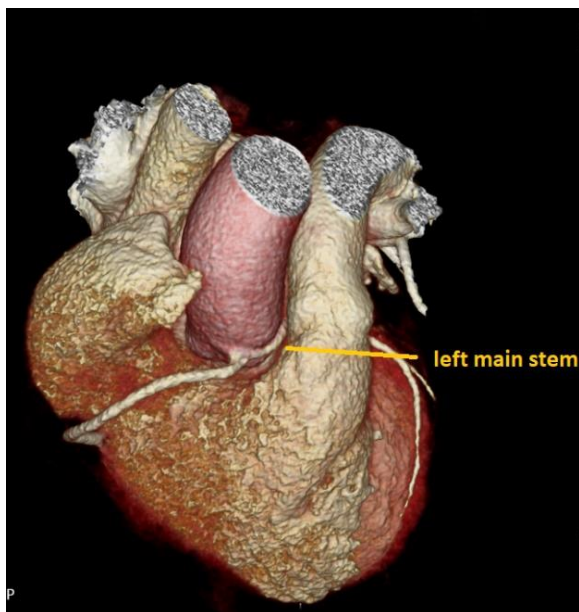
3D CT image showing the origin of the left main stem from the right cusp and its interarterial course.
